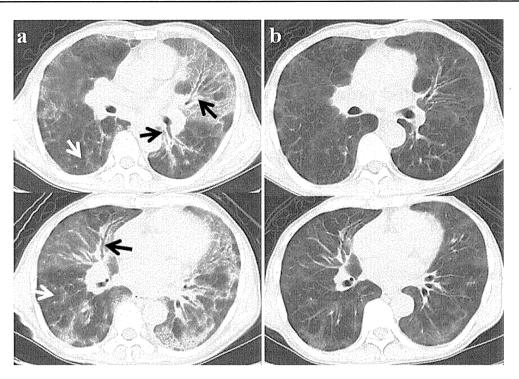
Chest computed tomography (CT) scan image showed diffuse ground-glass opacity, interlobular thickening (*white arrows*), and bronchial wall thickening (*black arrows*) (a). There was rapid improvement within 1 month after treatment initiation (b)
